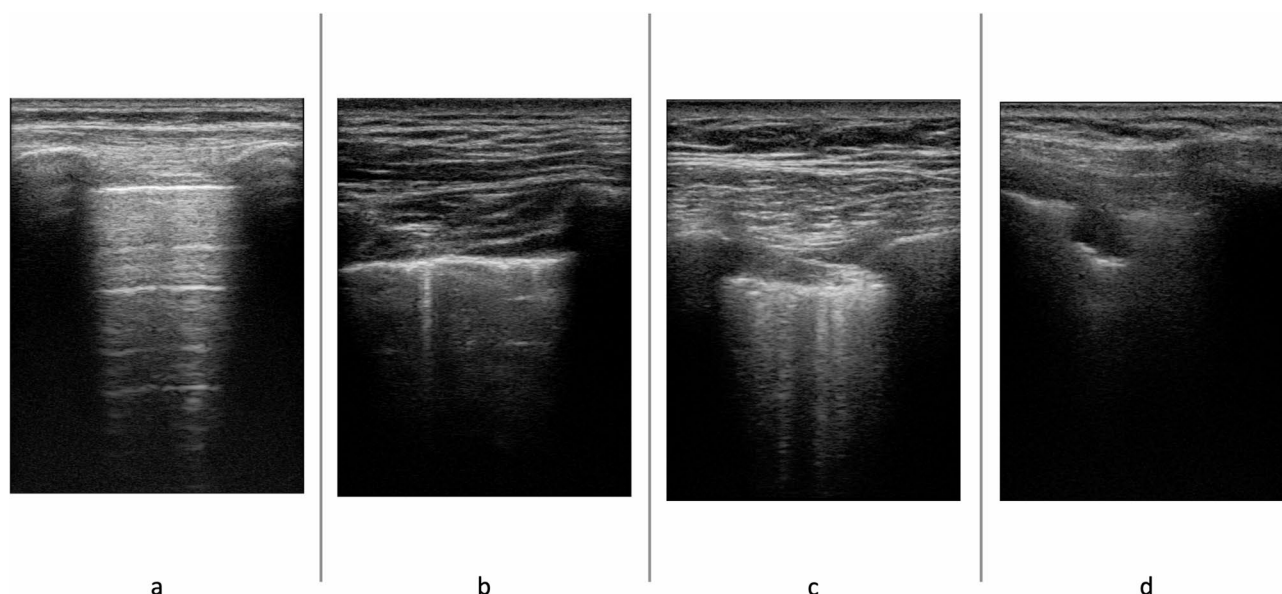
Characteristics of lung ultrasound findings in the study cohort a Normal pattern: observed in 54/271 (20.7%). Features: Smooth, homogeneous pleural line with regular gliding; A-lines as hyperechoic horizontal lines, equidistant and parallel to the pleural line. b Pleural line irregularities and B-lines: observed in 198/261 (75.9%). Features: Discontinuous or interrupted pleural line; B-lines as hyperechoic, vertical artefacts perpendicular to the pleura, mobile with respiratory movement, and obscuring A-lines. c Presence of ≥ 3 B-lines per segment: identified in 100/261 patients (38.3%). Features: Multiple vertical hyperechoic lines, mobile with pleural sliding, obscuring A-lines, with ≥ 3 per field. d Subpleural consolidations: observed in 93/261 patients (35.6%), with a size ≥ 1 cm in 3 cases (1.1%). Features: Hypoechoic subpleural images with pleural line disruption
